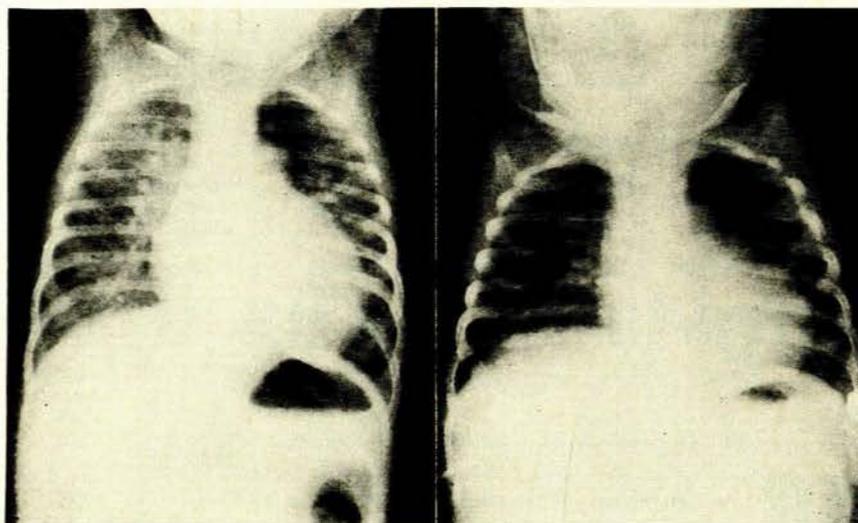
(a). Anteroposterior view of chest X-ray of patient D.G. before surgery, showing cardiomegaly, pulmonary plethora and dilated main pulmonary artery.
